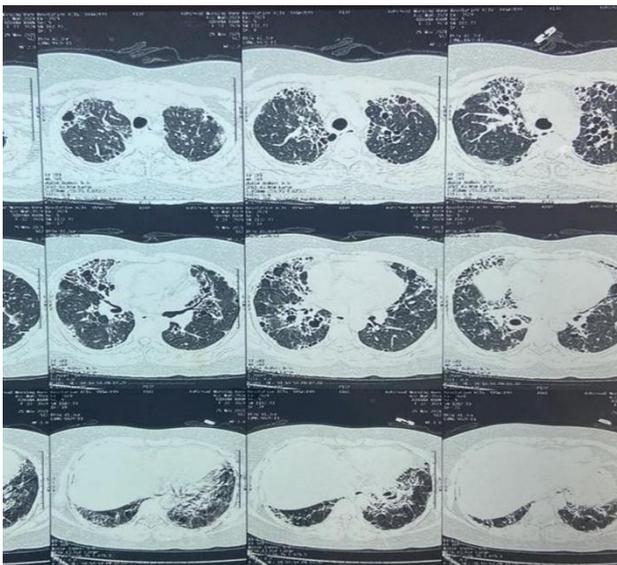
HRCT thorax of ILD-UIP pattern.
